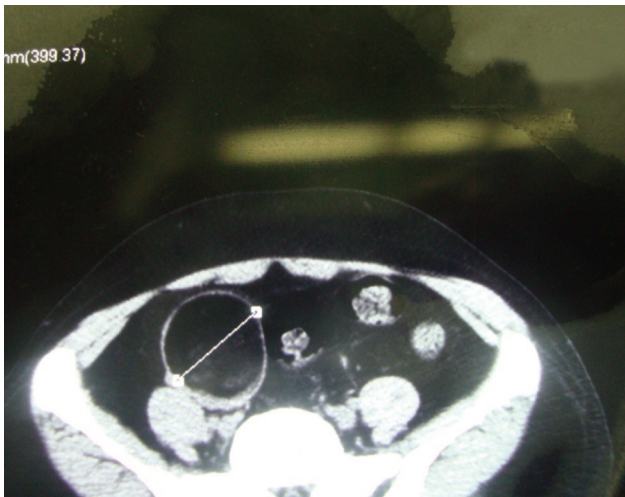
Pelvic CT scan showing the right ovarian cyst marked on the left side and remnant of the resected left ovarian cyst (right side).
